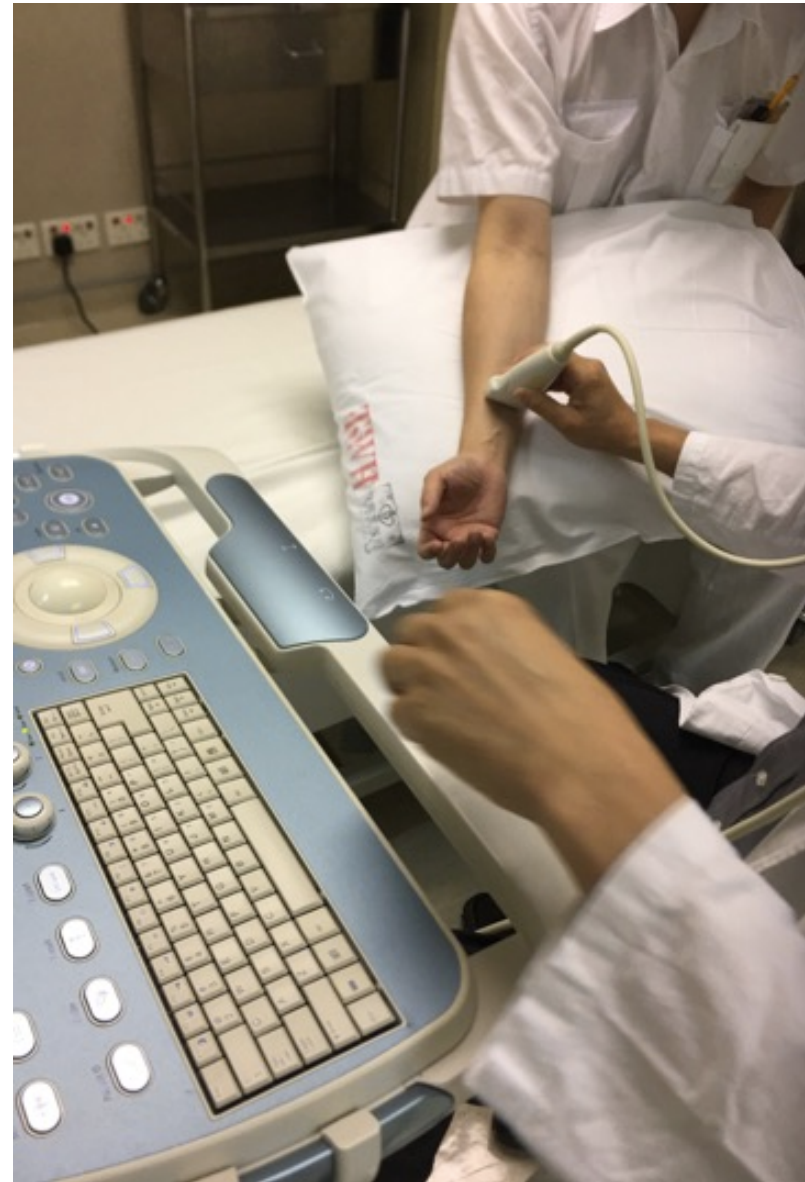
Measurement by ultrasound
